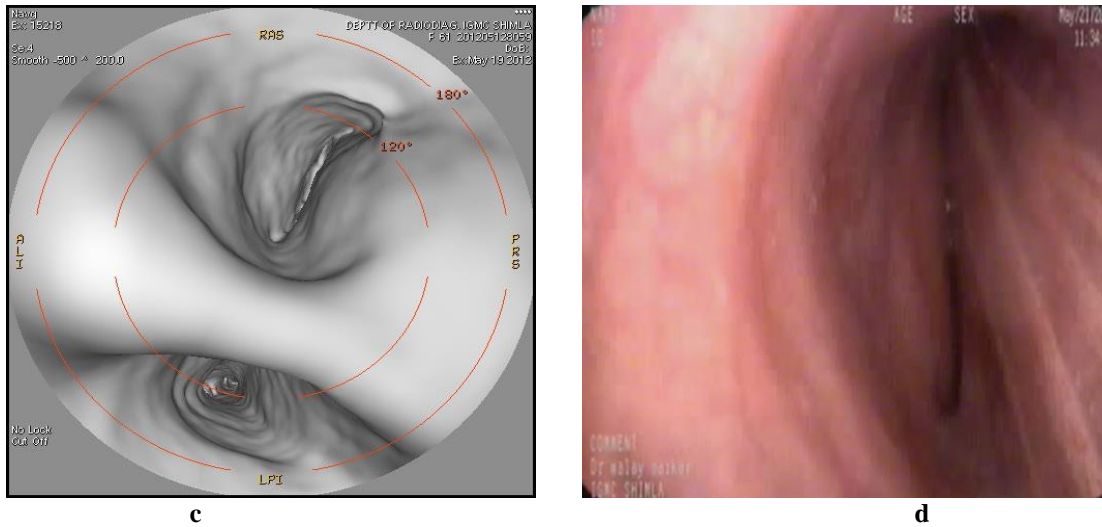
60 year old woman, non-smoker, who presented with cough and chest pain. a: Contrast enhanced axial CT image (mediastinal window) shows a large heterogeneous mass compressing the RUL bronchus causing severe stenosis. b: MPR in lung window shows extrinsic compression of the RUL bronchus and its segmental branches. However, they are patent. c: VB shows extrinsic compression at RUL bronchus. This caused severe stenosis. However, VB could pass this stenosis and explore airways beyond the lesion. d: FOB also showed extrinsic compression at RUL bronchus. However, distal patency could not be assessed. Bronchial brushings revealed adenocarcinoma.
